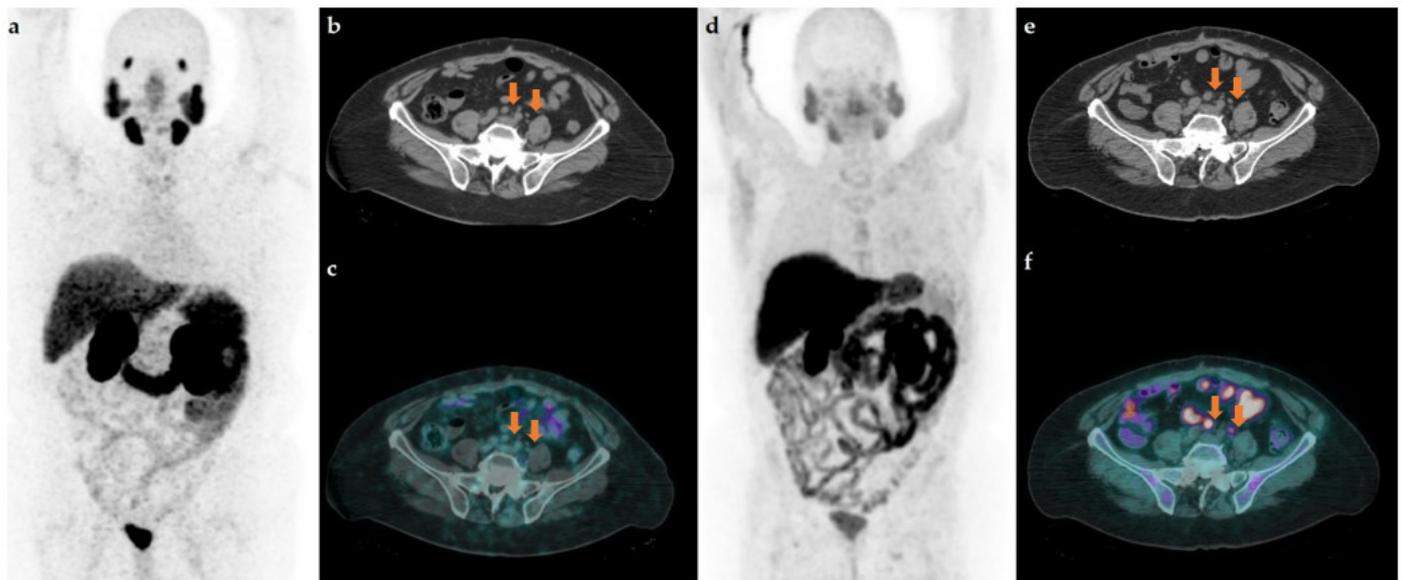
Maximum intensity projection (MIP) (a), axial low-dose CT (b) and fused ^{68}Ga]PSMA-11 PET/CT (c); MIP (d), axial low-dose CT (e) and fused ^{18}F]Choline PET/CT performed 16 days after PSMA PET/CT (f).
